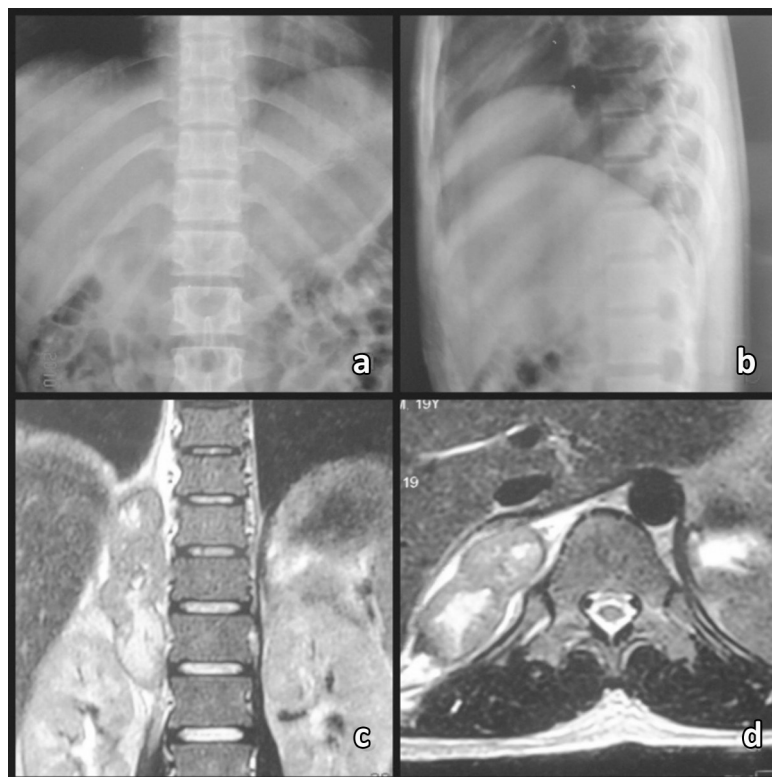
a, b - Antero-posterior and lateral views of thoracic spine showing no abnormalities. c, d - MRI coronal and axial films showing right paravertebral mass.
